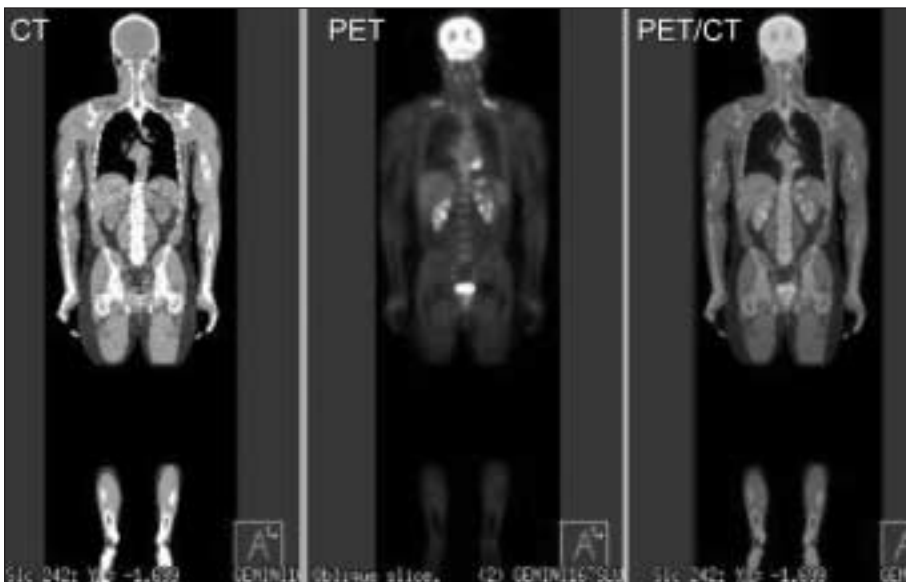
True whole-body F-18 FDG-PET/CT from the top of the head to the soles of the feet.
